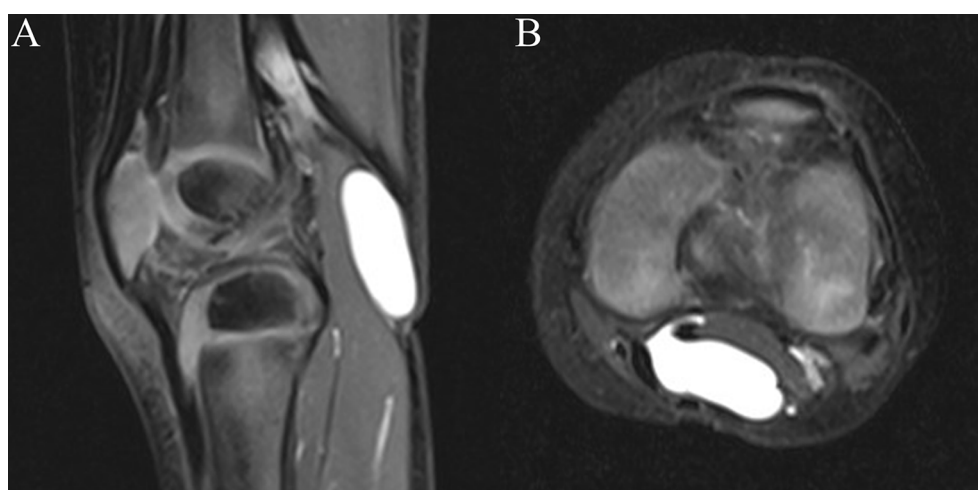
(A) Sagittal MRI of popliteal cyst. (B) Cross-sectional MRI of popliteal cyst
